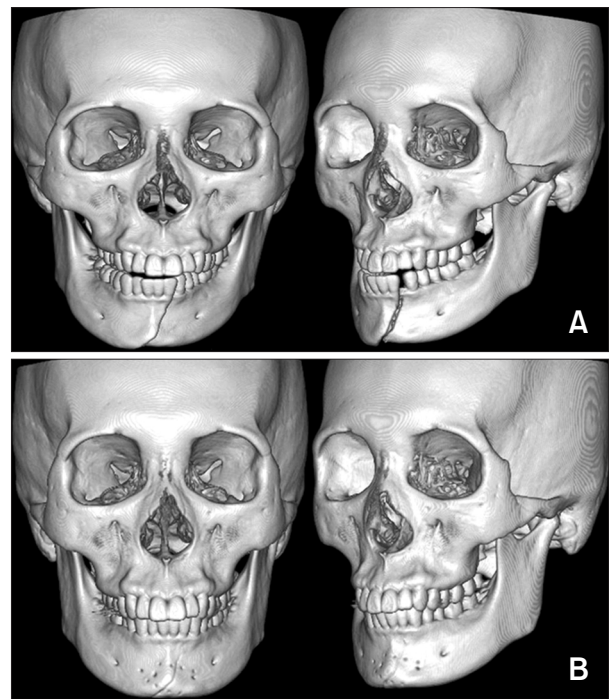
(A) Computed tomography (CT) shows a mandible body fracture on the symphysis region. (B) Postoperative CT image shows favorable fixation of the mandible body.
